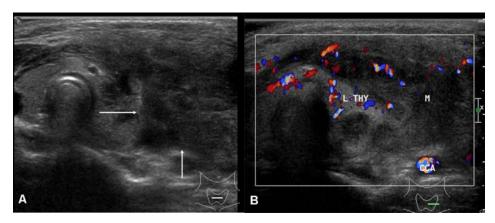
Transverse ultrasound shows an ill-defined non-homogeneous hypoechoic lesion (arrows) at the left lobe of thyroid and perithyroidal area (A) with increased vascular perfusion (B). L THY = left lobe of thyroid gland, M = mass lesion and CCA = left common carotid artery
